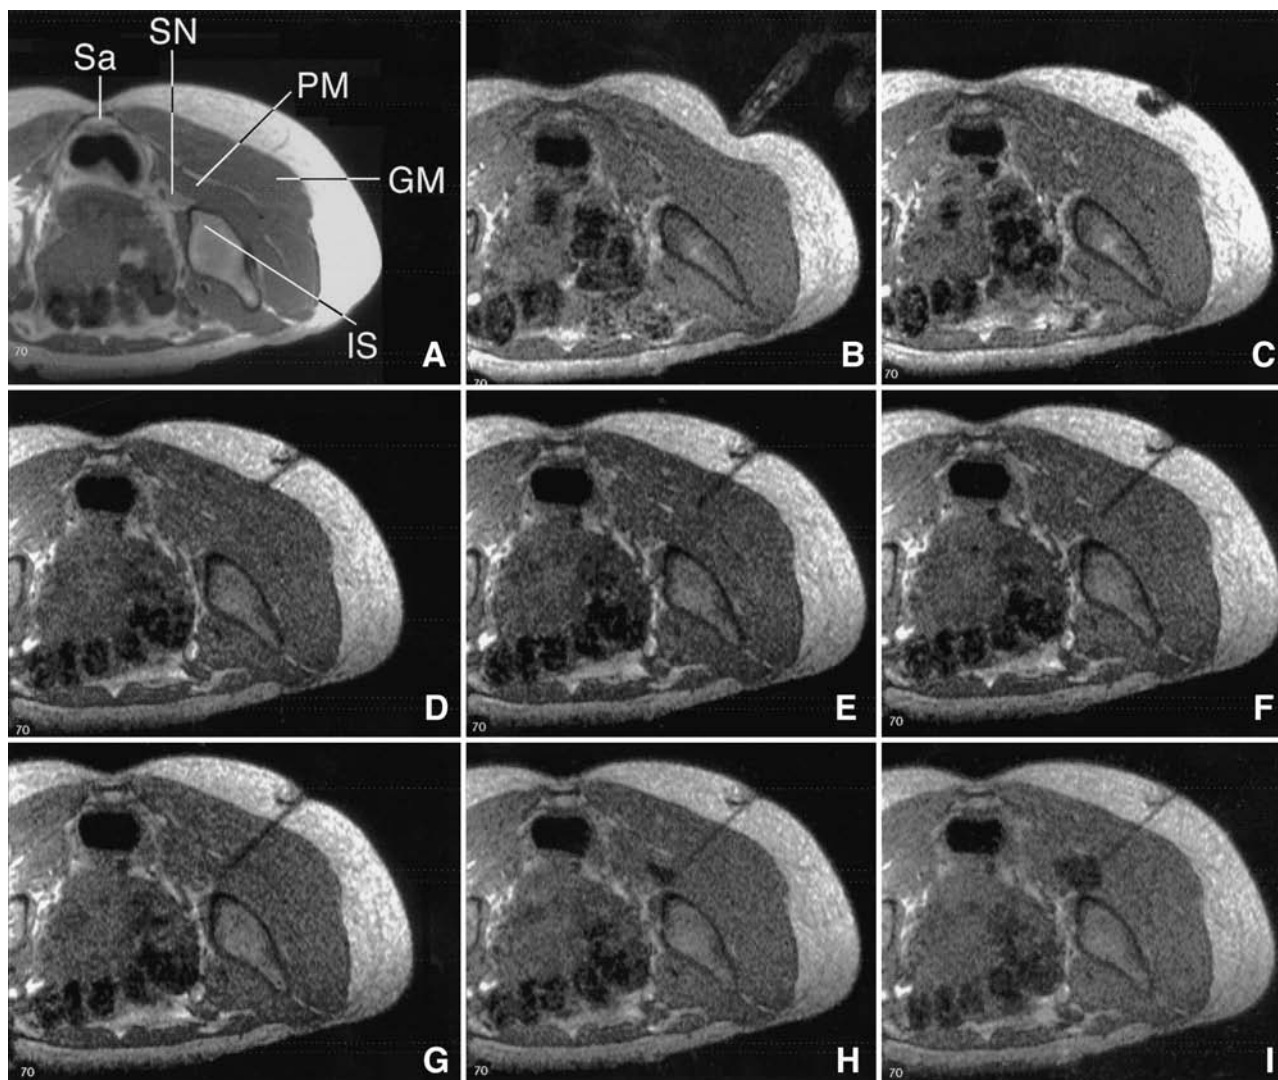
Open MR imaging-guided piriformis muscle injection. A: A  $T_1$ -weighted image. GM = gluteus maximus, IS = ischium, PM = piriformis muscle, Sa = sacrum, SN = sciatic nerve. B: Physician's finger indicating approach. C: Subcutaneous local anesthetic. D–G: Titanium Lufkin needle advanced into piriformis muscle. H & I: Marcaine injection darkens the muscle (the images in B–I were 14-second, two dimensional fast-low angle shot images.)
